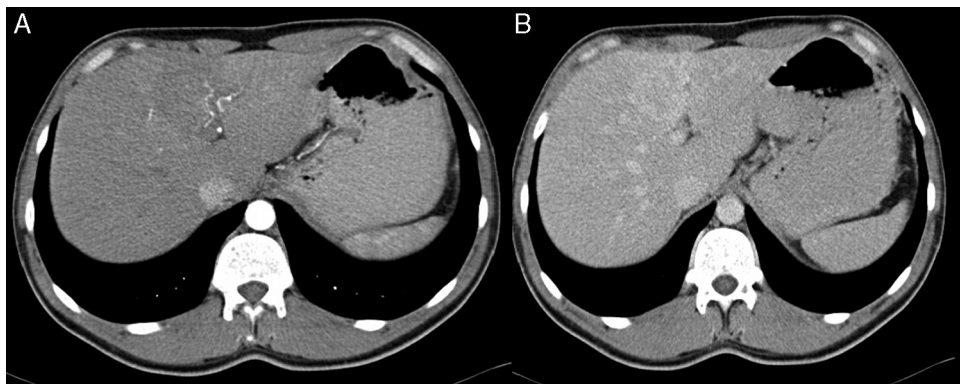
Contrast-enhanced computed tomography scan: low enhanced lesion in the arterial phase (A), with progressive enhanced in the late phase (B).
